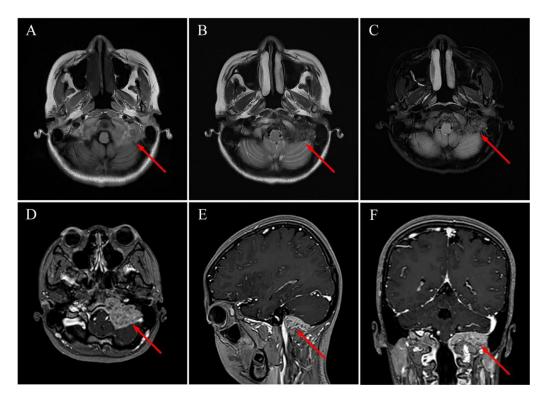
MRI findings. T1WI and T2WI depict an irregular mass in the left jugular foramen region with adjacent bone intensity alterations. The lesion exhibits low and slightly low intensities, and there is compression of the adjacent left cerebellar hemisphere (A, B). T2 fat suppression sequences reveal low intensity within the lesion with hyperintense spots (C); T1WI enhancement scans demonstrate significant heterogeneous enhancement of the lesion, which encircles and invades the left internal jugular vein, accompanied by multiple bone destructions. Importantly, the lesion does not invade the adjacent brain parenchyma (D-F).
